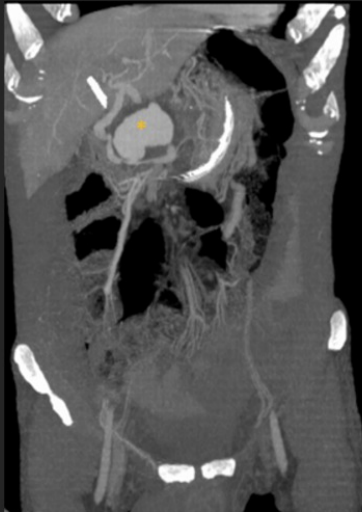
Imaging techniques in gastrointestinal haemorrhage - computed tomography (CT) angiography key point analysis
